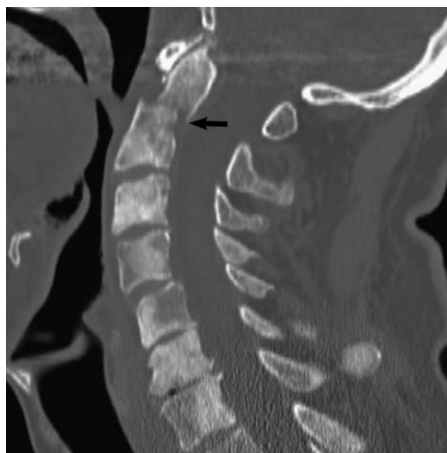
Sagittal CT reformat shows typical cervical spine blastic metastatic lesions and a pathologic dense fracture (*arrow*) in this patient with prostate cancer, who fell and struck his chin.
